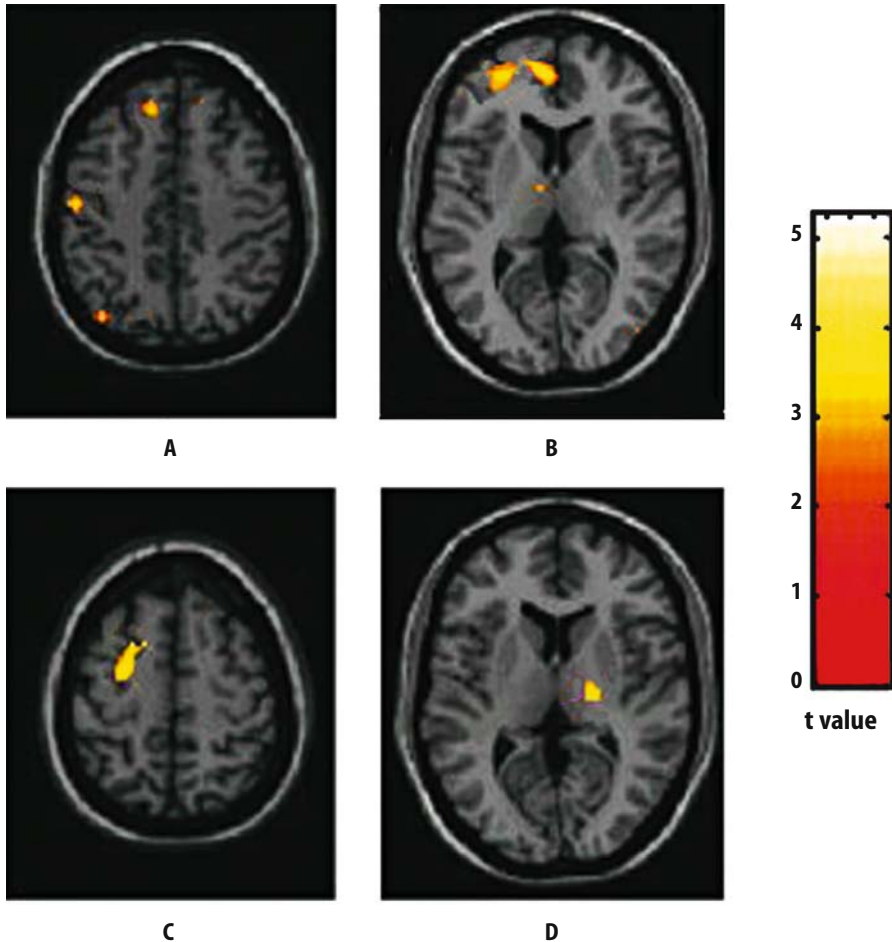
Relative cortical activations of MS patients with reversible fatigue after IFN β -1a injection during the performance of a simple motor task with their clinically unimpaired and fully normal functioning, dominant right hands. At entry (A, B) (when they did not complain of fatigue), compared with MS patients without reversible fatigue, these patients showed an increased recruitment of the contralateral primary SMC (A), the thalamus (B), the superior frontal sulcus (A, B), and the cingulate motor area (B). At time 1 (C, D) (when fatigue was present), compared with MS patients without fatigue, these patients showed increased recruitment of the ipsilateral thalamus (D), and contralateral middle frontal gyrus (C). Note that the color-coded activations have been superimposed on a high-resolution T1-weighted scan obtained from a single, healthy subject and normalized into standard statistical parametric mapping space (neurological convention). From [43], with permission
